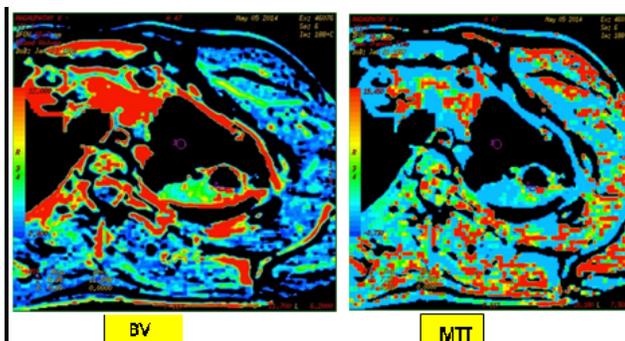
CT Perfusion in normal lungs
